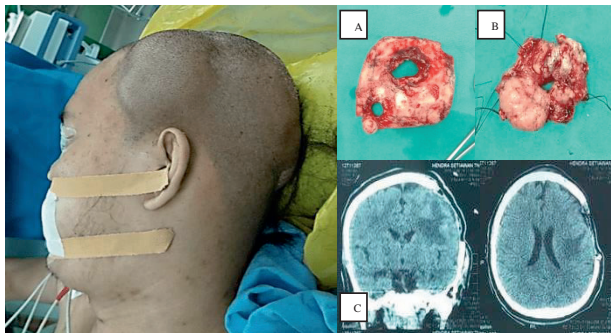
Clinical conditions of the left parietal region of the tumor on the patient's head. A) Post resection calvaria tissue, B) Resected tumor tissue, C) CT scan of the head post-operative evaluation
